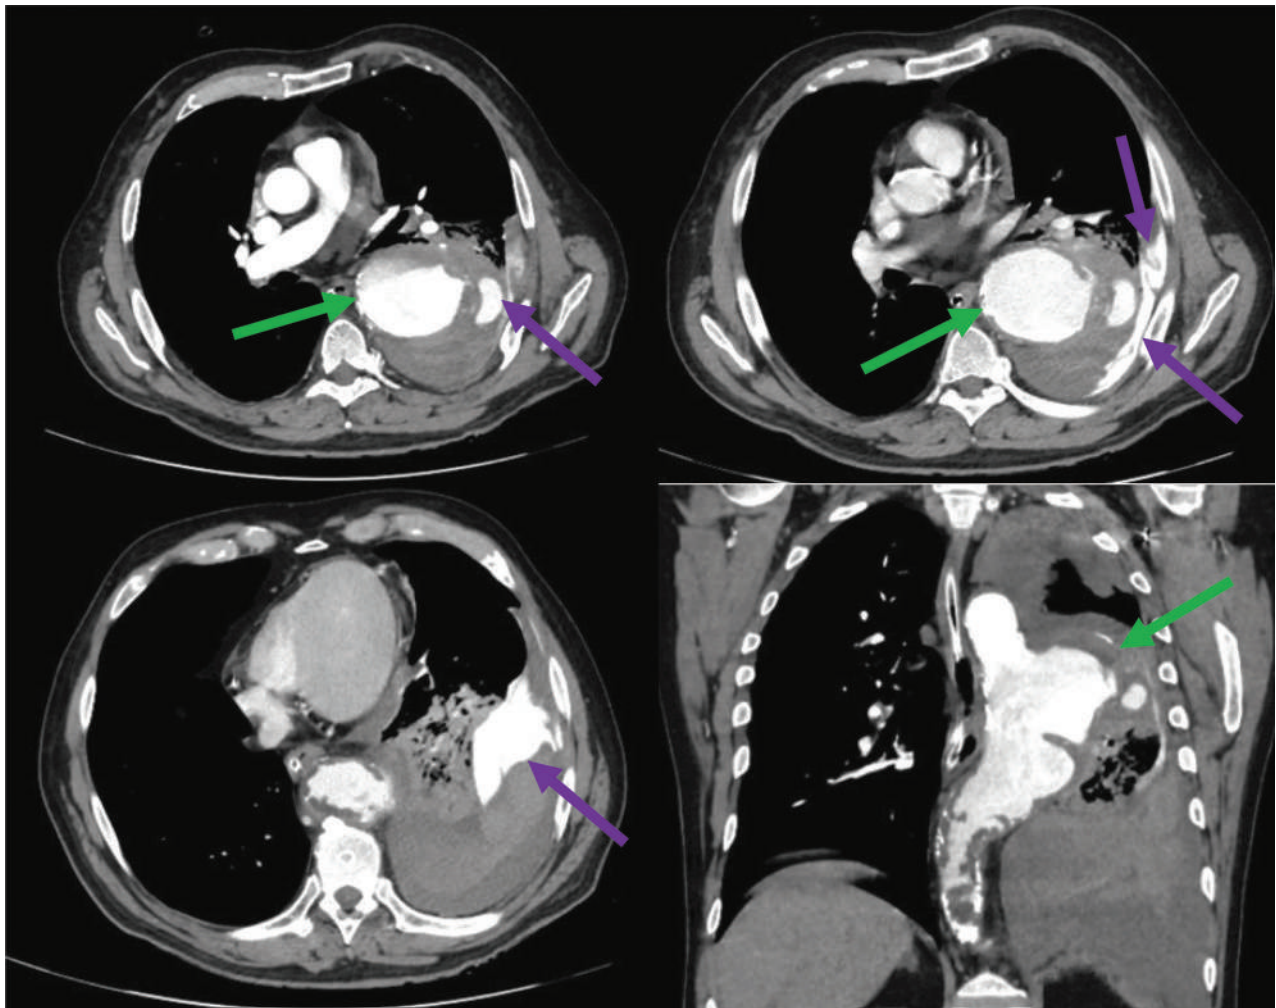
Contrast-enhanced CT acquisitions - arterial phase - axial and coronal sections.
